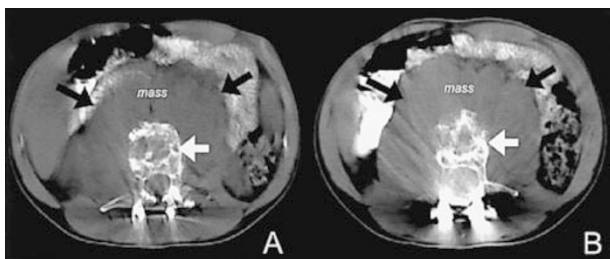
(A,B) Two consecutive slices of CT demonstrating the destruction of the third lumbar vertebral body (white arrows) and the large mass encircling the vertebra (black arrows)
